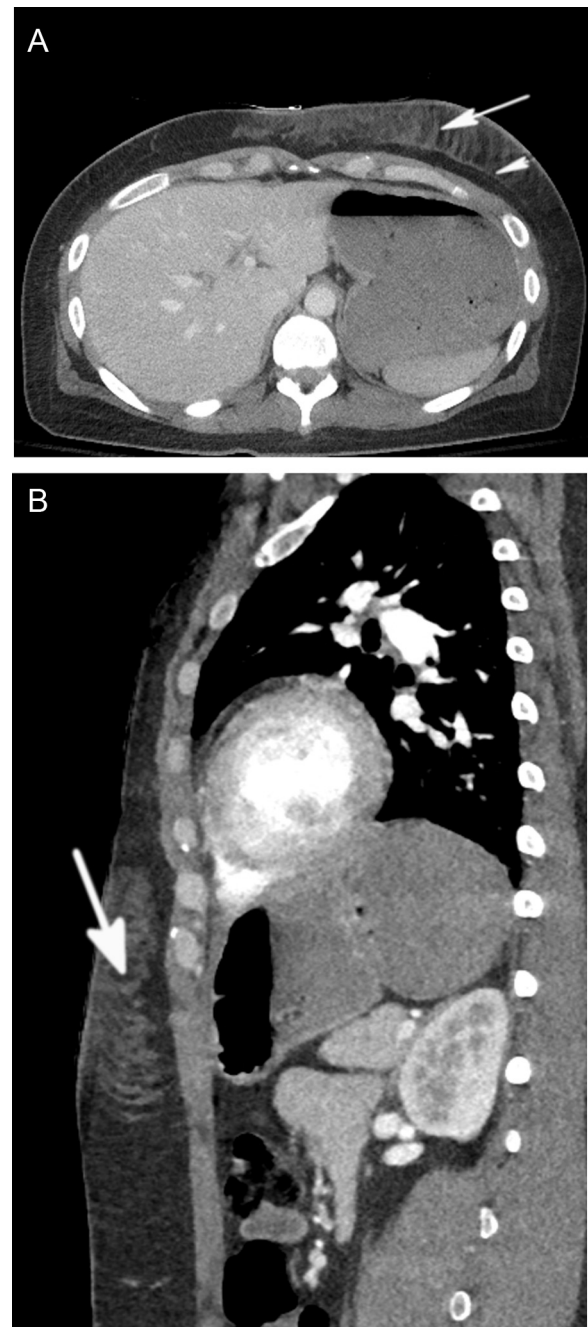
CT scan of full thickness burn injury. A 31-year-old female after motor vehicle collision. (A) Axial image of CT of abdomen with IV contrast shows subcutaneous stranding extensively involves left anterior abdominal wall. Some of the stranding involves the subcutaneous fat lobules and forms thick bank-like or polygonal densities (arrow) above the deep fascia (arrowhead). Soft tissue beneath the deep fascia layer and the underlying rectus abdominis muscle are intact without evidence of injury. (B) Sagittal CT image shows subcutaneous stranding extensively involving the subcutaneous layer of abdominal wall.
